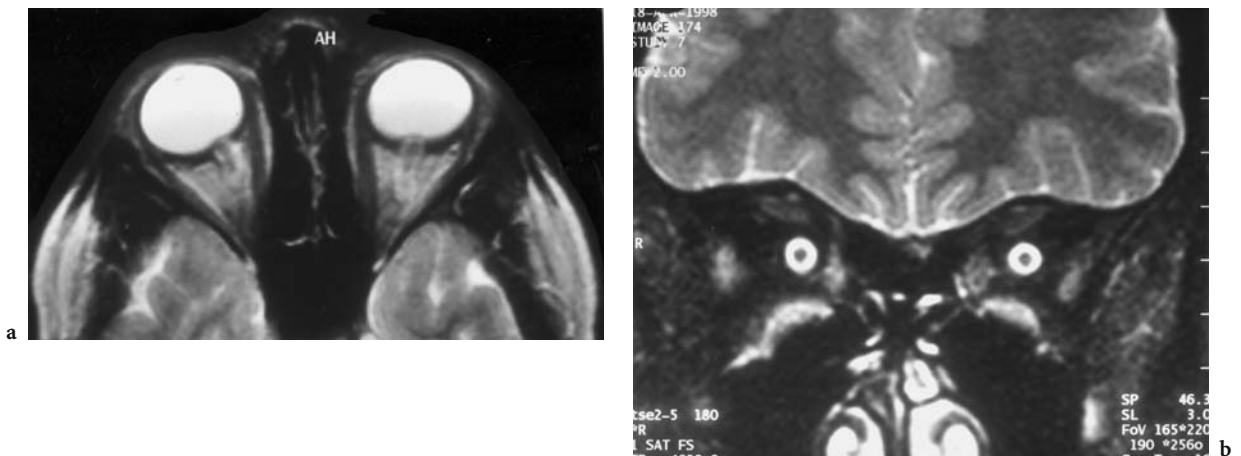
A 24-year-old woman with chronic papilledema. Diagnosis: cerebral pseudotumor. MRI: a Axial T2-weighted view demonstrating the impression of the papilla by the optic nerves. b Coronal T2-weighted view with enlargement of the subarachnoid space of the intraorbital optic nerve sheath
